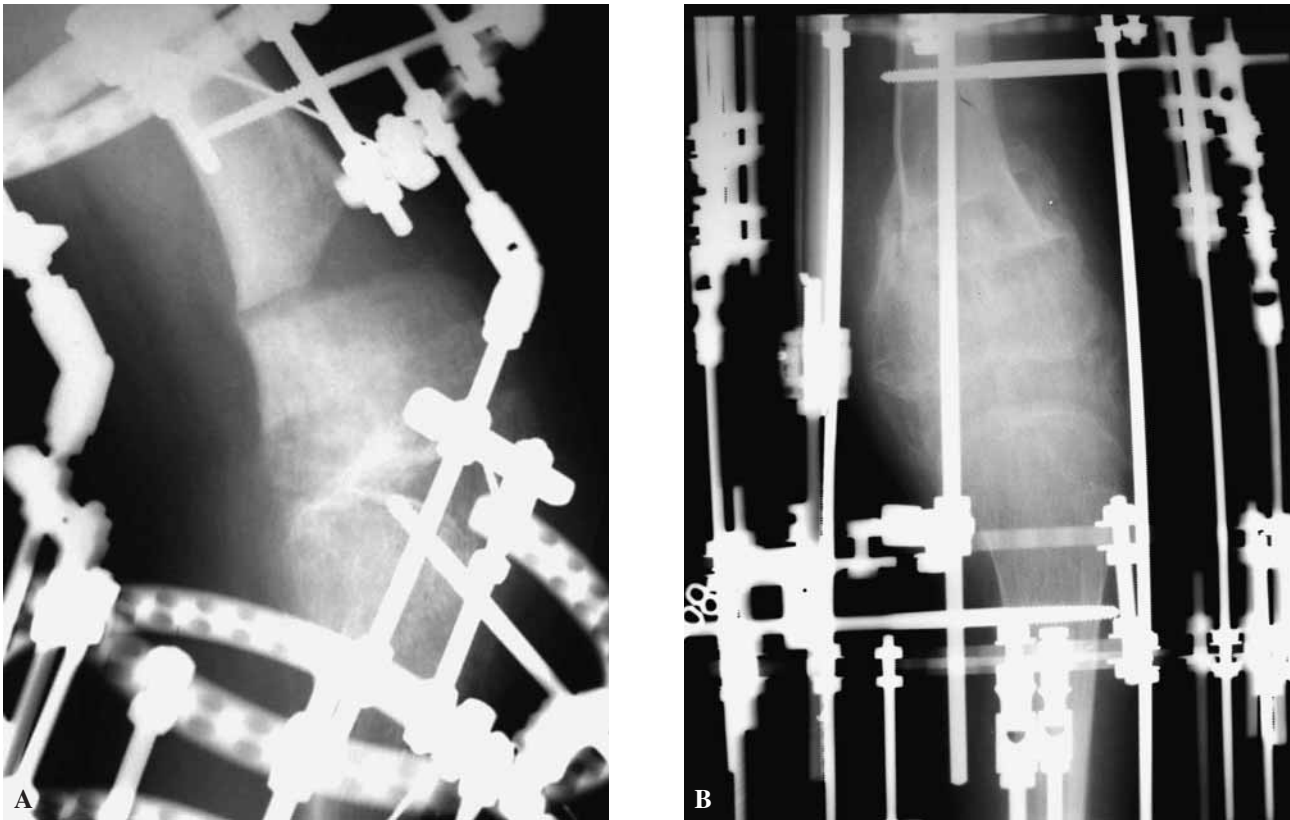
A : Lateral radiograph of the wedge resection osteotomy. Note that the hinges correspond to the peak of the osteotomy. B : Radiological appearance after correction of deformity (AP view).
